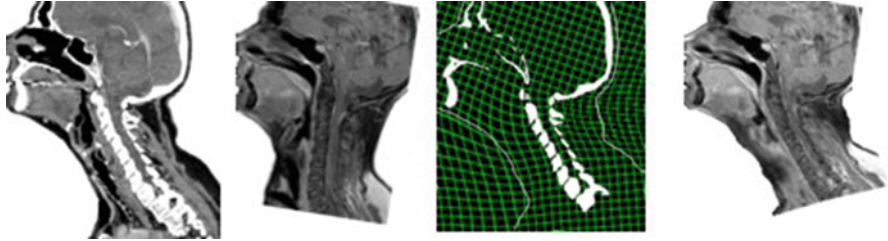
Skeleton-based deformable registration of CT/MR images. After segmentation, for each bone, a single rigid transformation is successively found based on the maximization of an image similarity metric. Finally, those transformations are propagated into the surrounding soft tissue, resulting in a dense deformation field
